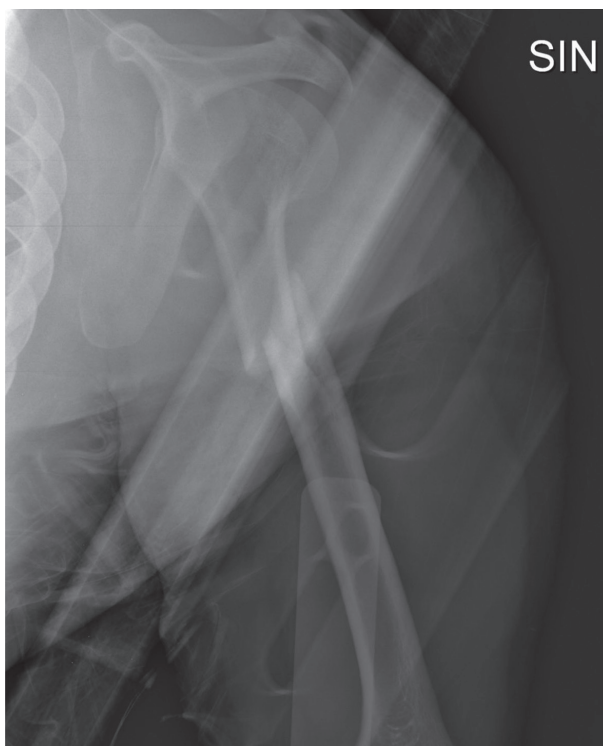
Preoperative X-ray (sagittal view)
